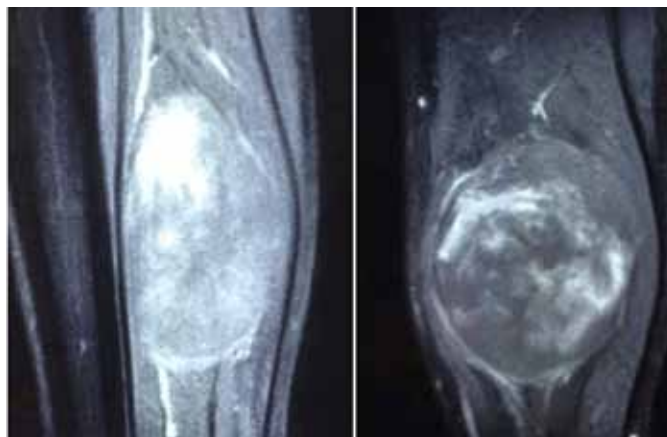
T1-weighted Magnetic resonance imaging scans of tumor.
